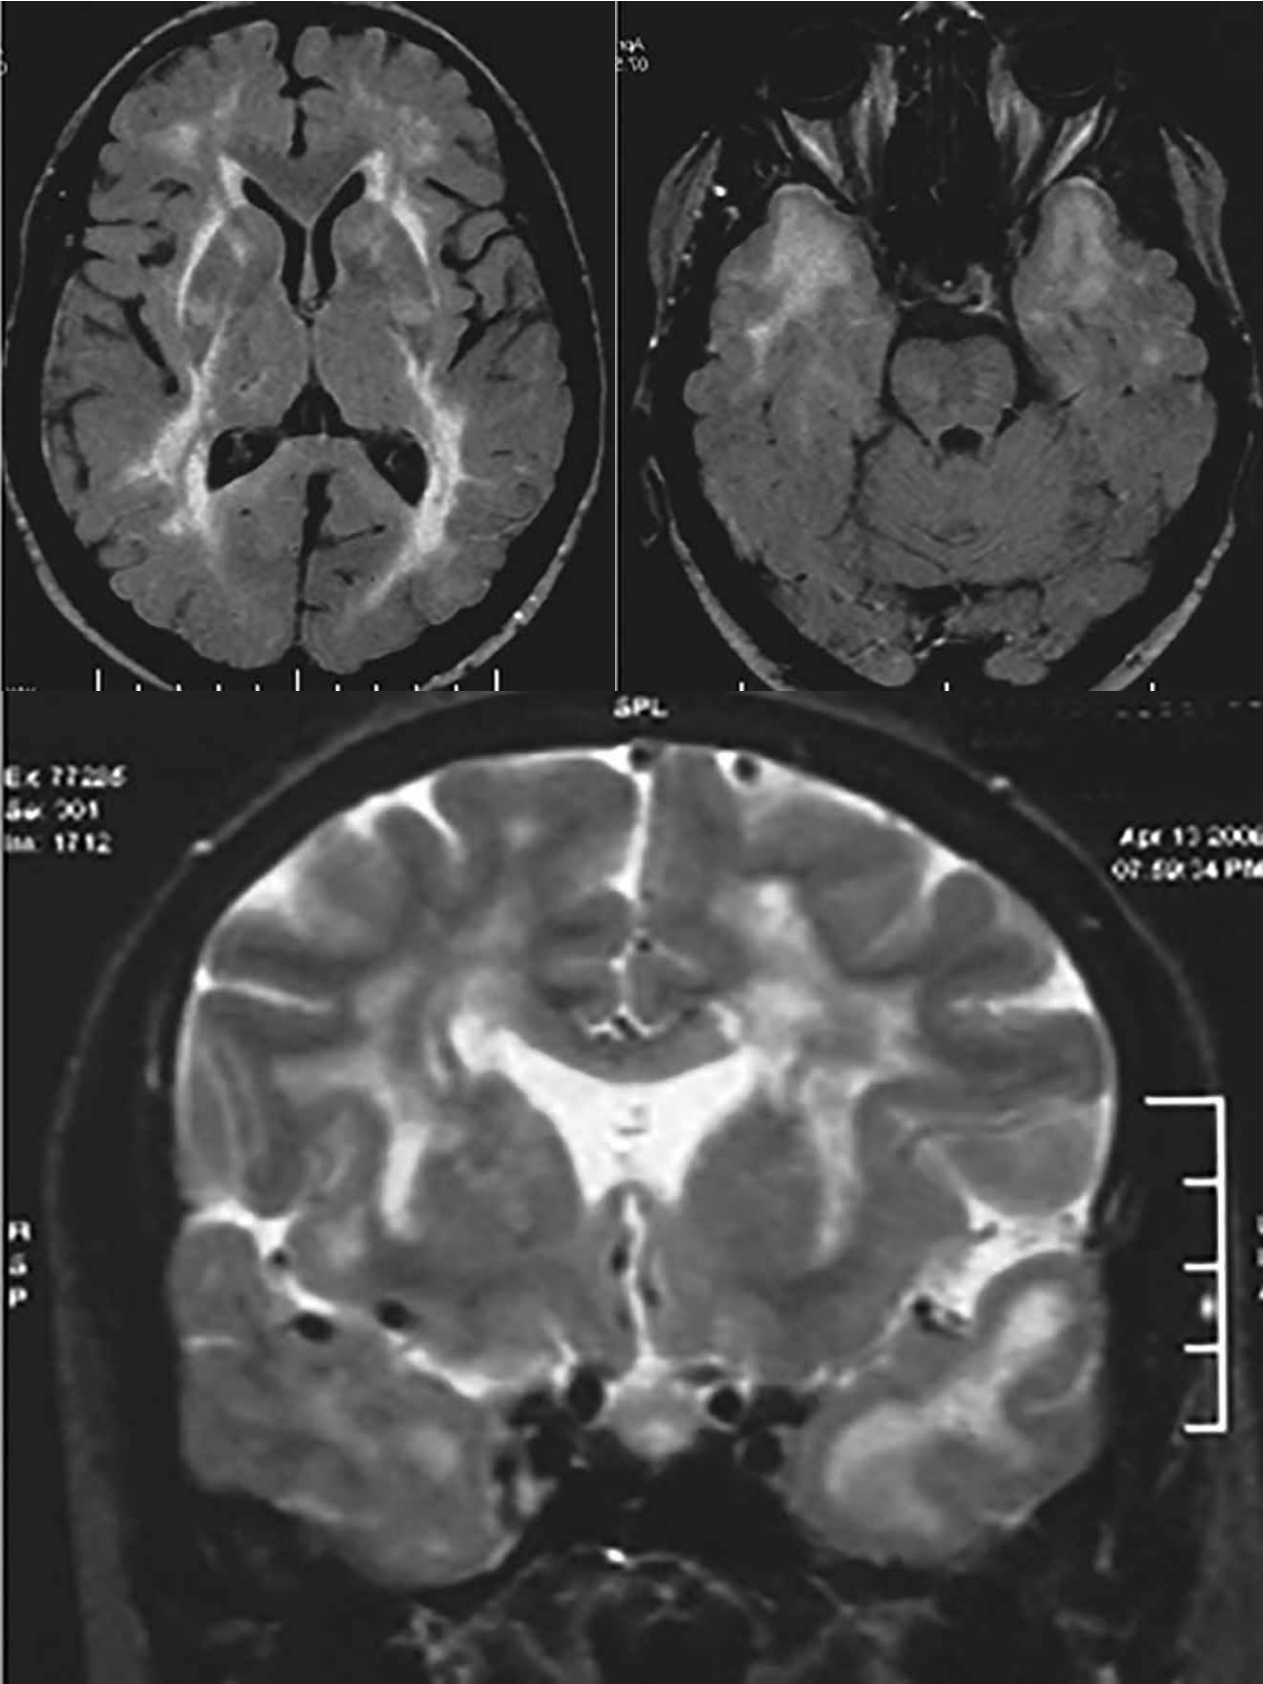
CADASIL, MRI (a, b - T2W FLAIR axial; c - T2W coronal).
